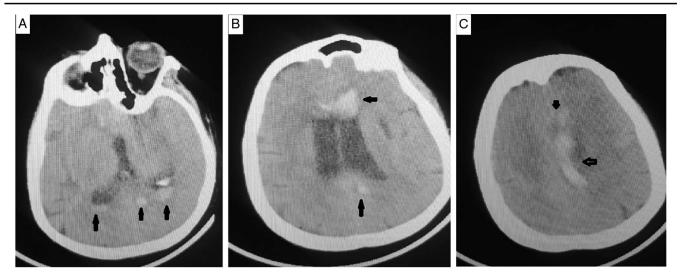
A noncontrasted CT of the brain, axial view, showing foci of intracerebral hemorrhage surrounded by edema (black arrow) and intraventricular hemorrhage (hollow arrow).
